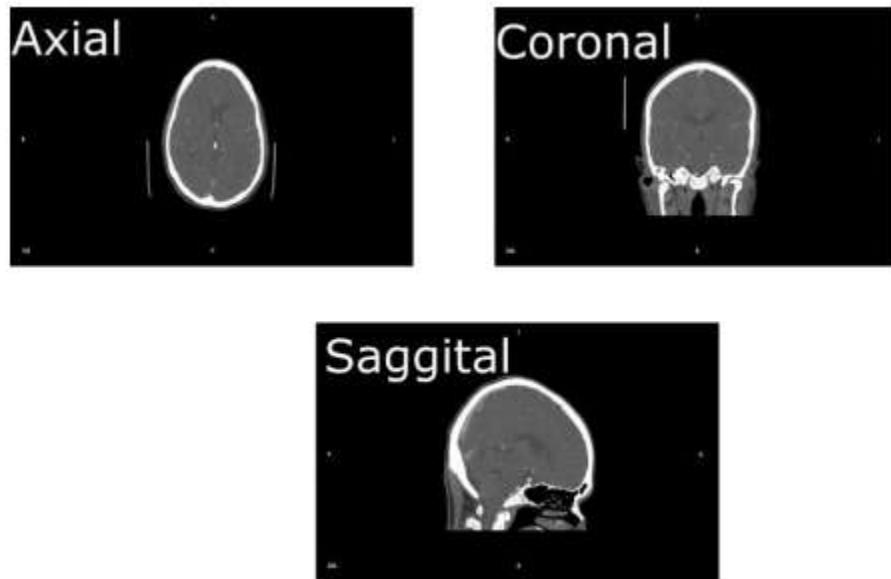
CT scan of human Head
